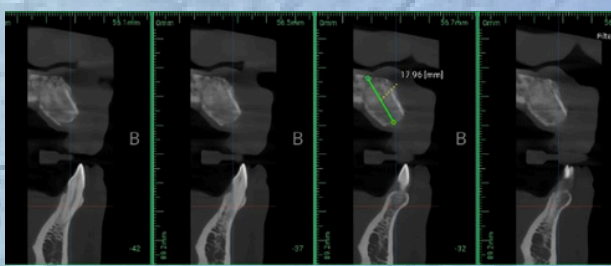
CBCT cross section images showing vertical bone gains 10.96mm from the baseline of 7 mm
